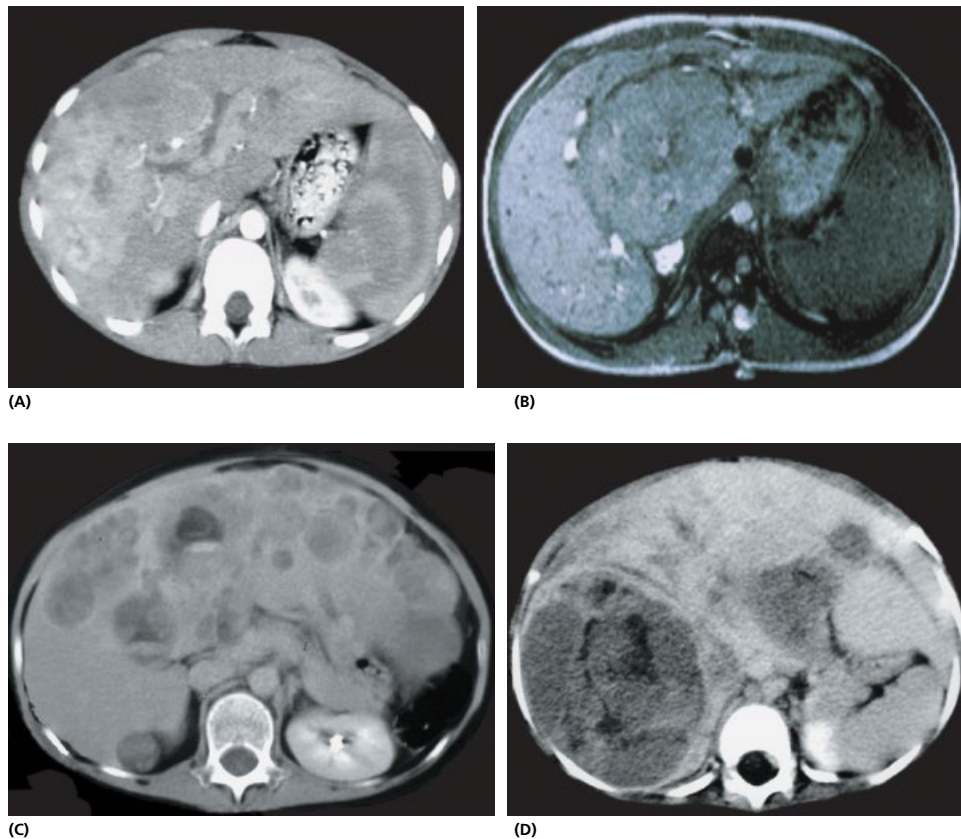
Computed tomography appearances of hepatocellular carcinoma. (A,B) Fibrolamellar hepatocellular carcinomas. (C,D) Classic hepatocellular carcinomas, originating in normal liver. Hepatocellular carcinomas are usually multifocal and invasive, commonly involving both lobes at diagnosis. Areas of hemorrhage and necrosis are common in the usual type. Vascular invasion and thrombosis (portal or hepatic veins) are usually associated with rapid progression and a poor short-term prognosis. Fibrolamellar hepatocellular carcinomas are fibrous, solid tumors, often better delineated, and have remarkably slow growth.
